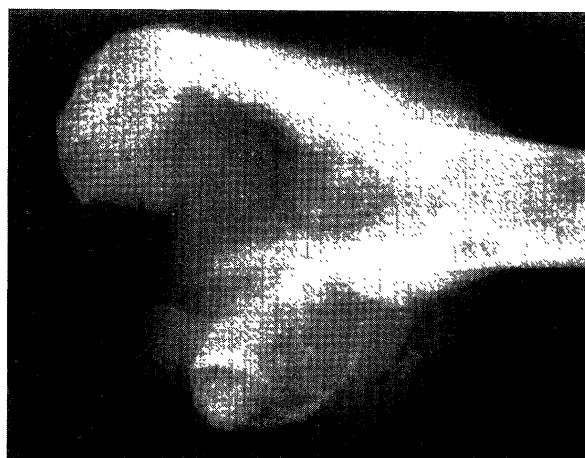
Posteroanterior radiograph of the right humerus showing a lytic, lightly trabeculated lesion at the condyle.
